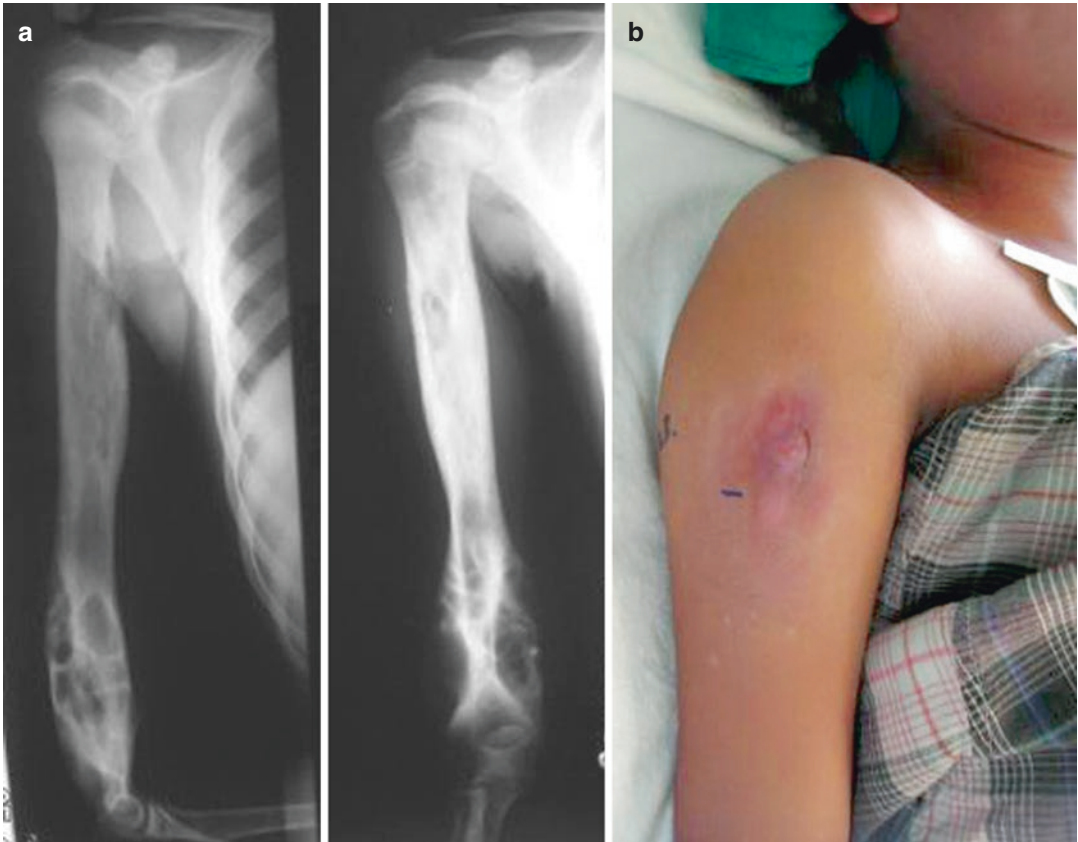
(a) X-ray of hydatid osteomyelitis of the right humerus. (b) Chronically draining sinus of hydatid osteomyelitis
